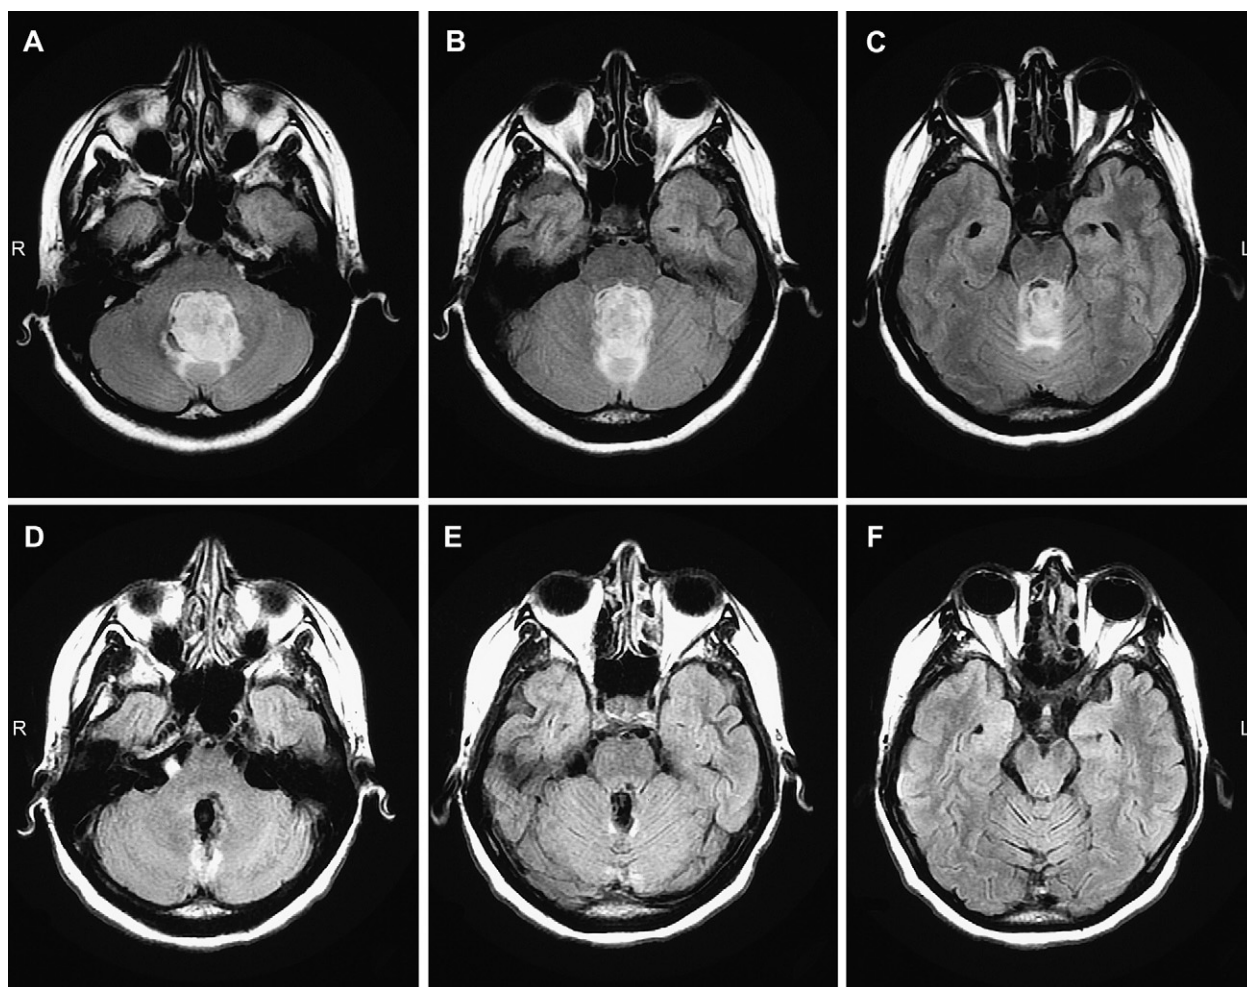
Brain MRI axial T2-weighted FLAIR slices on admission (A–C) disclosing a hyperintense tumoural mass lesion in the fourth ventricle with a diameter of approximately 27.5 mm and early postoperative T2-weighted FLAIR slices (D–F) showing near-total resection of a low-grade ependymoma.
